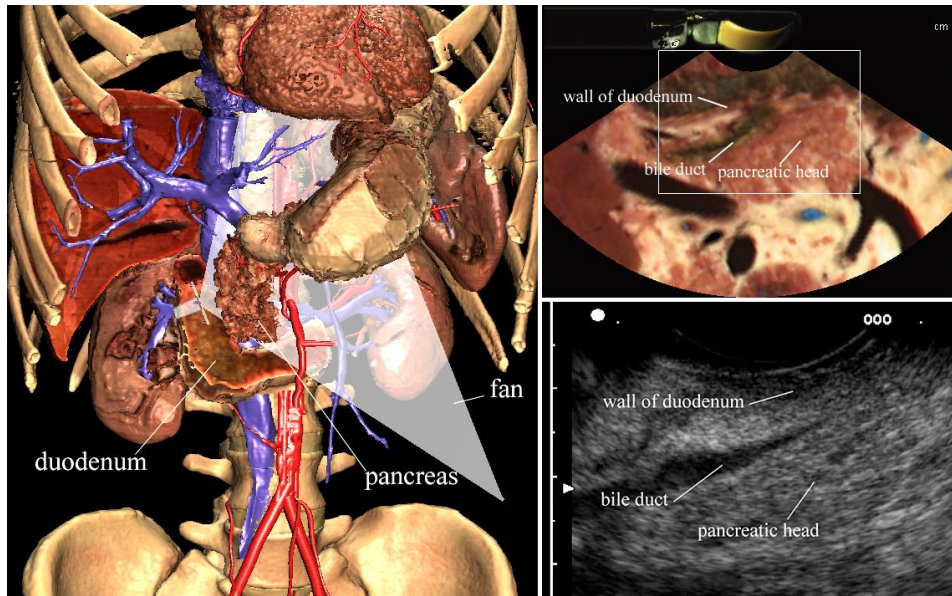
Training system for linear type endoscopic ultrasonography (EUS). The probe (left) is placed in the duodenum, with the view directed to the pancreas. The resulting cross-section (upper right) can be examined and interrogated as to the shown anatomical constituents. The ultrasound image (lower right) shows an analogous view from a patient examination.
